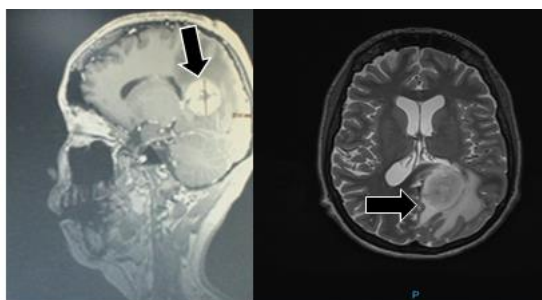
Magnetic Resonance Image showing brain tumor in axial and sagittal section (arrows).
